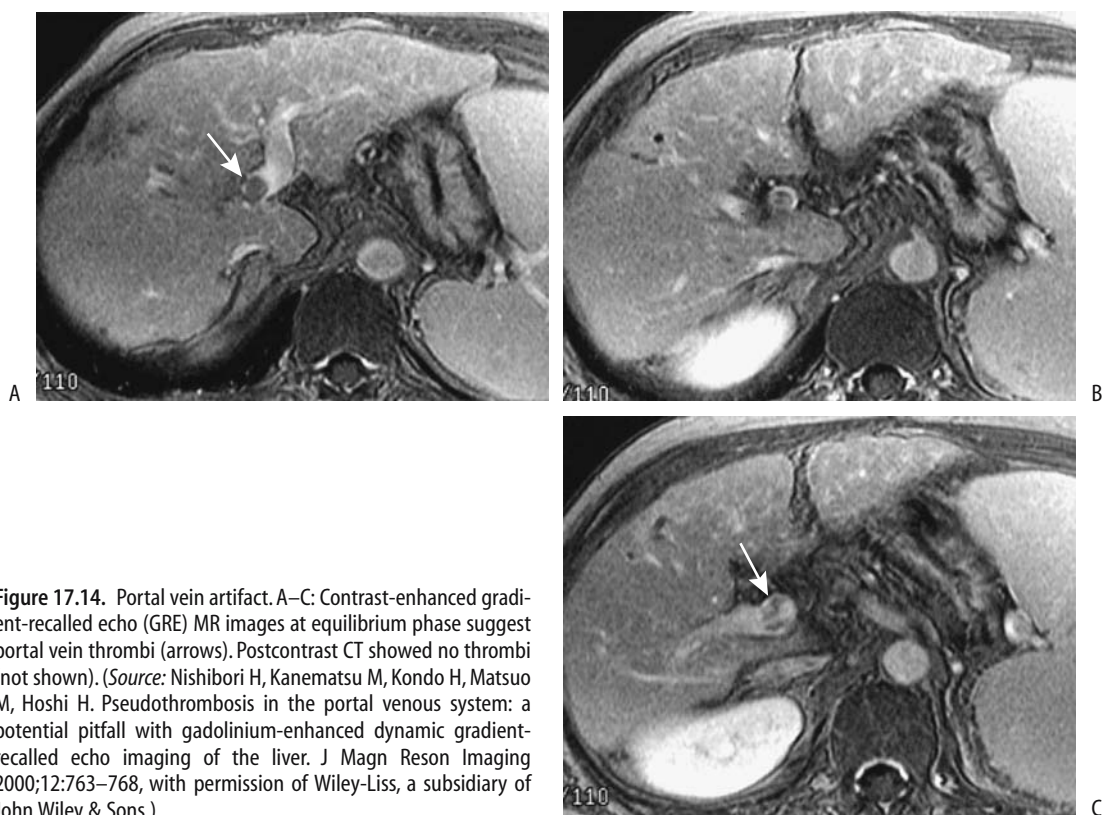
Portal vein artifact. A–C: Contrast-enhanced gradient-recalled echo (GRE) MR images at equilibrium phase suggest portal vein thrombi (arrows). Postcontrast CT showed no thrombi (not shown). (Source: Nishibori H, Kanematsu M, Kondo H, Matsuo M, Hoshi H. Pseudothrombosis in the portal venous system: a potential pitfall with gadolinium-enhanced dynamic gradient-recalled echo imaging of the liver. *J Magn Reson Imaging* 2000;12:763–768, with permission of Wiley-Liss, a subsidiary of John Wiley & Sons.)
